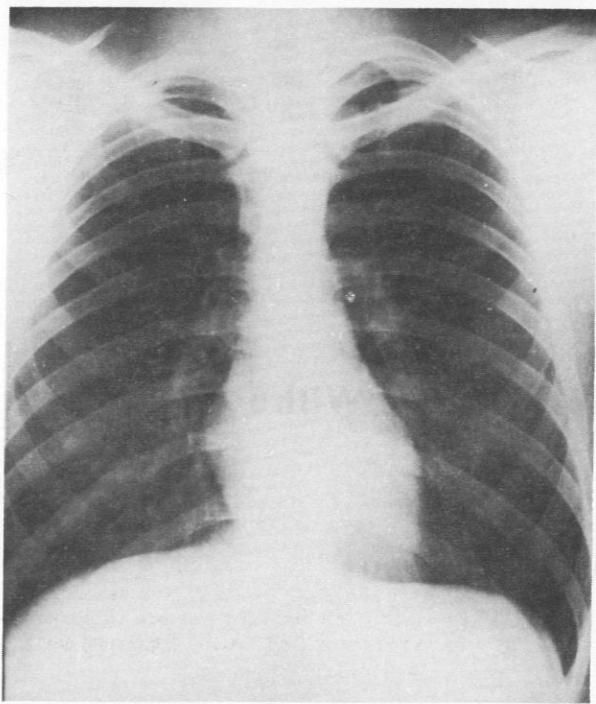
Preoperative thoracic roentgenogram. Absence of an aortic knob; no descending aorta or rib notching is visible.
